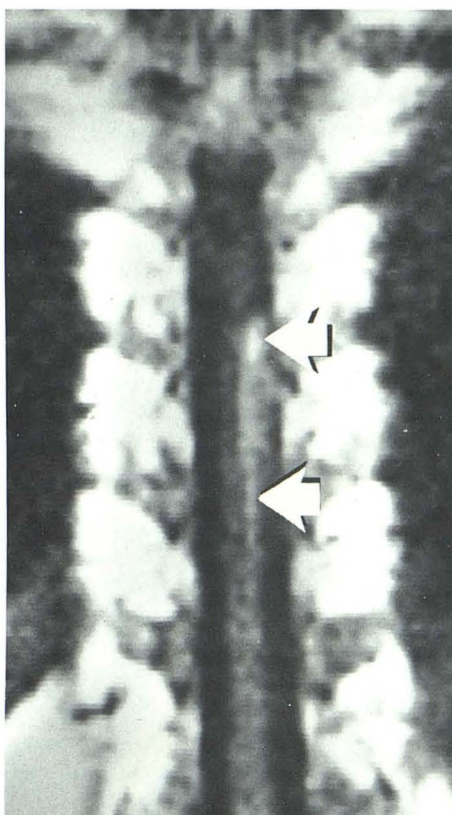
Sagittal (A) and coronal (B) MR images obtained with standard body coil using a 10-mm slice. TR = 600 msec, TE = 30 msec. A linear area of hyperintensity (arrows) is seen on both images. Lateral plain film (C) of lower thoracic spine reveals presence of residual intraspinal Pantopaque in a location corresponding to area of linear hyperintensity seen in A and B. Anteroposterior
